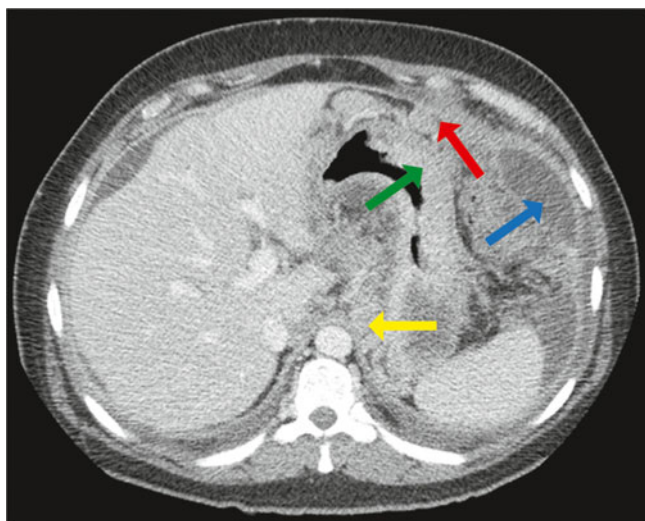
Computed tomography of the abdomen showed a thickened stomach wall (green arrow), a loculated fluid collection (blue arrow), paraaortic lymphadenopathy (yellow arrow), and omental carcinomatosis (red arrow).
